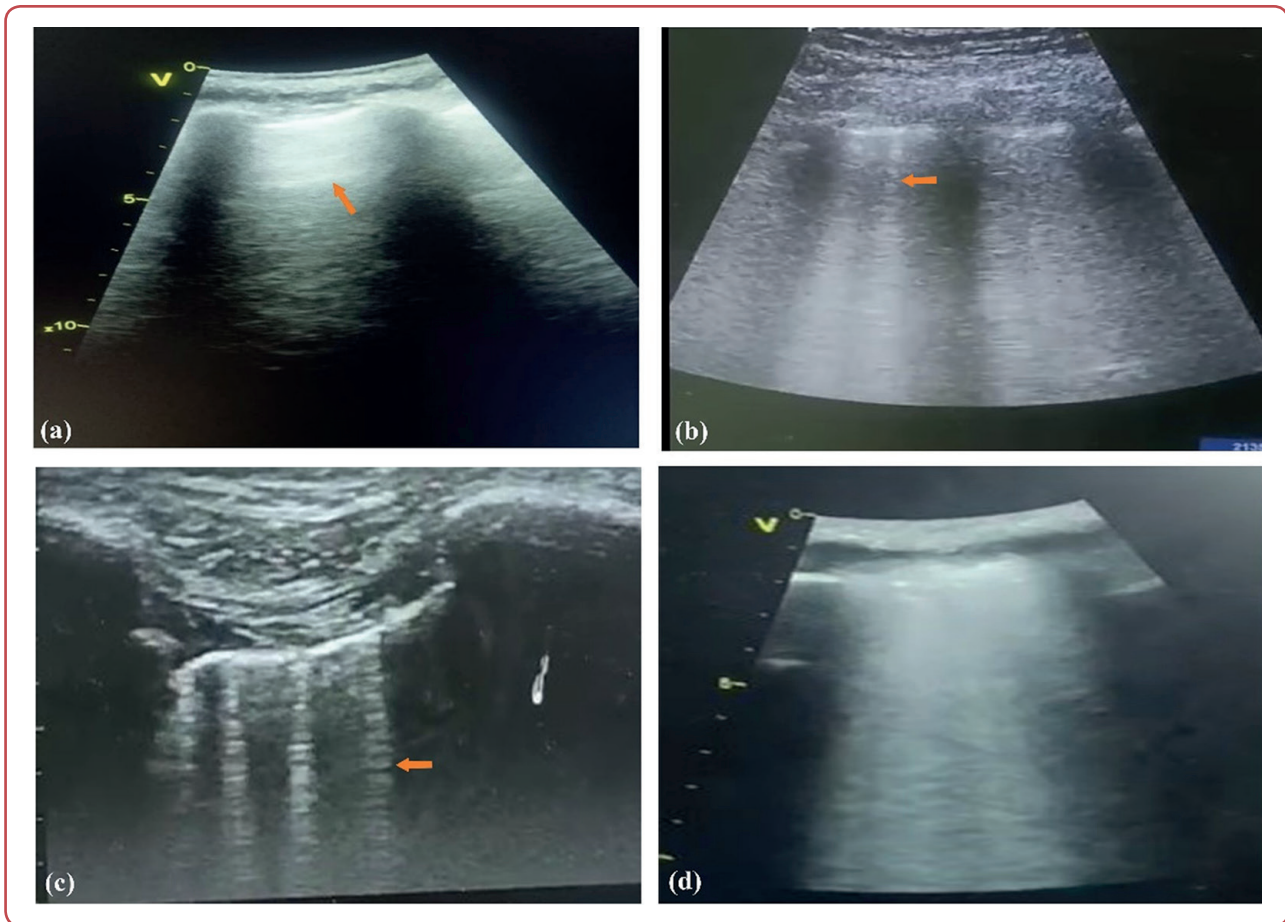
Lung ultrasound images
